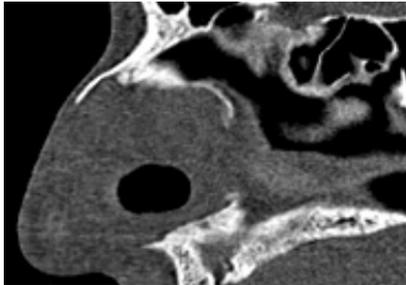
Sagittal CT scan. Septal perforation of the cartilaginous part of NS.
